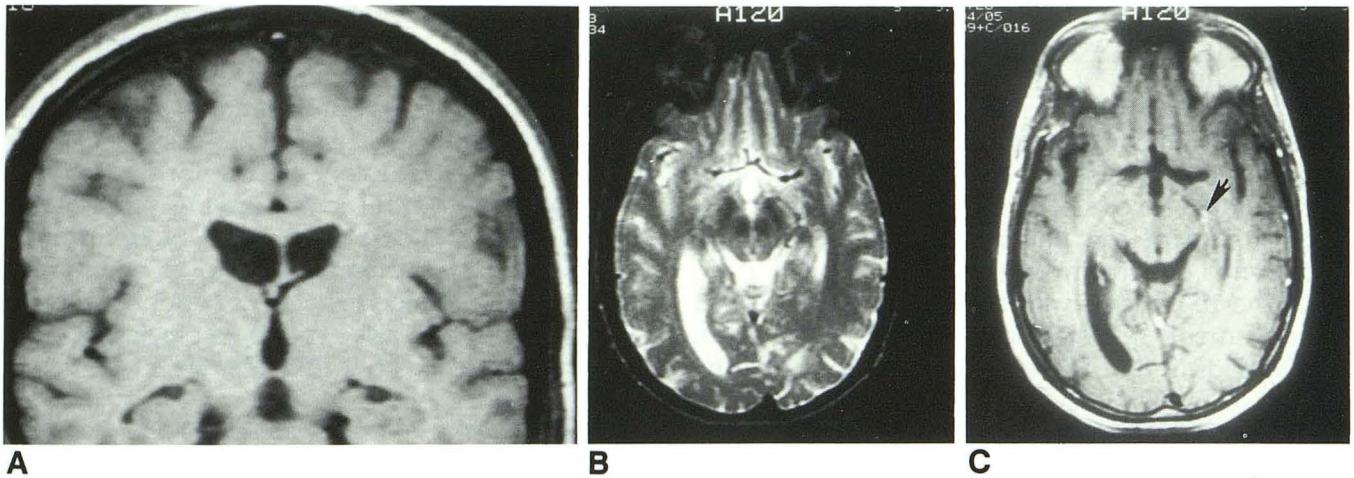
Patient with one mass lesion on precontrast images. A, T1-weighted (600/20) coronal and B, T2-weighted (2000/80) axial images reveal no definite mass near the left temporal lobe. Postcontrast T1-weighted (600/20) axial image (C) reveals an enhancing mass just above the left temporal horn (arrow), seen better on the corresponding (D) coronal T1-weighted (600/20) postcontrast image (arrows). A T2-weighted coronal sequence was not performed. Because this was the patient's second mass, he was empirically started on antitoxoplasmosis therapy.
